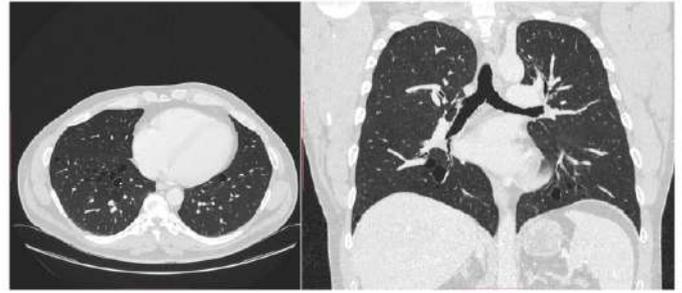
CT scan of a patient with Birt-Hogg-Dubé syndrome.
